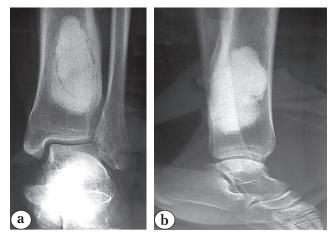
Postoperative plain radiographs after 5 years, anteroposterior (*a*) and lateral (*b*) views showing intact cement-bone interface, no pathological fracture, and no local recurrence
